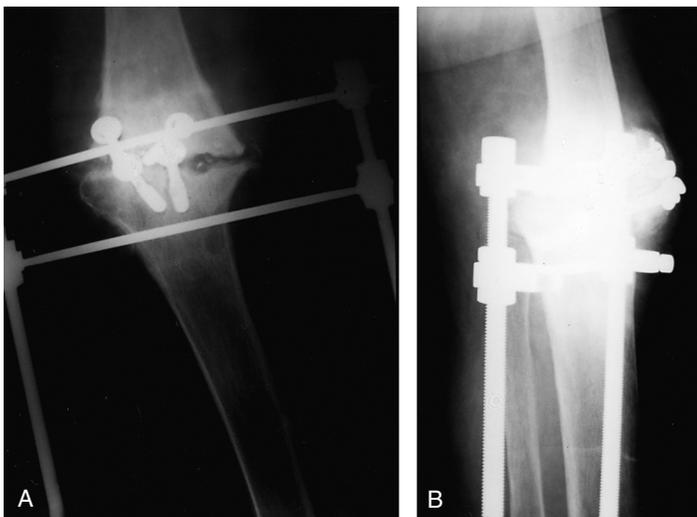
(A) Anteroposterior and (B) lateral radiographs of the same patient as in Figure 1 showing failed knee arthrodesis using a combination of lag screws and external fixation
